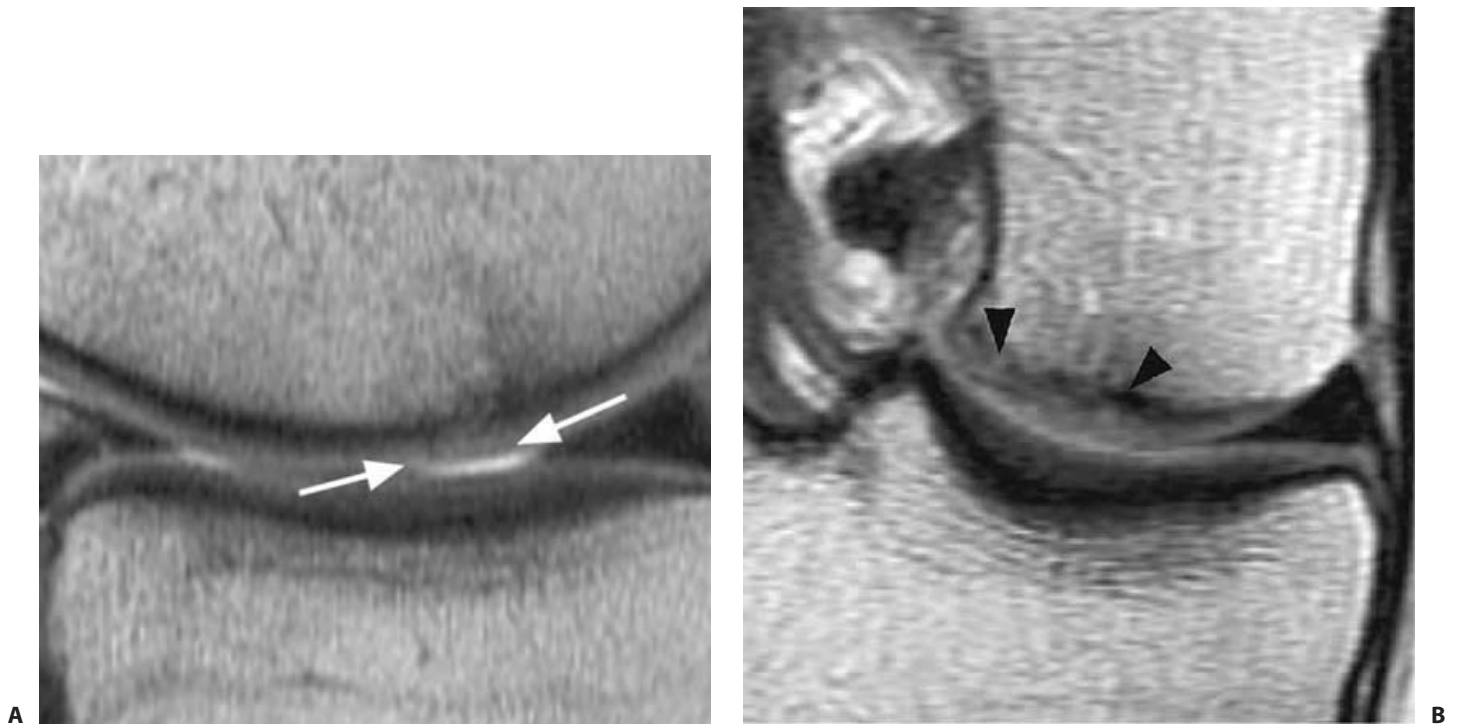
One-year postoperative magnetic resonance imaging (MRI) demonstrates on sagittal (A) and coronal (B) images that repair tissue is filling the defect area, where former microfracture was performed (*arrows*).
